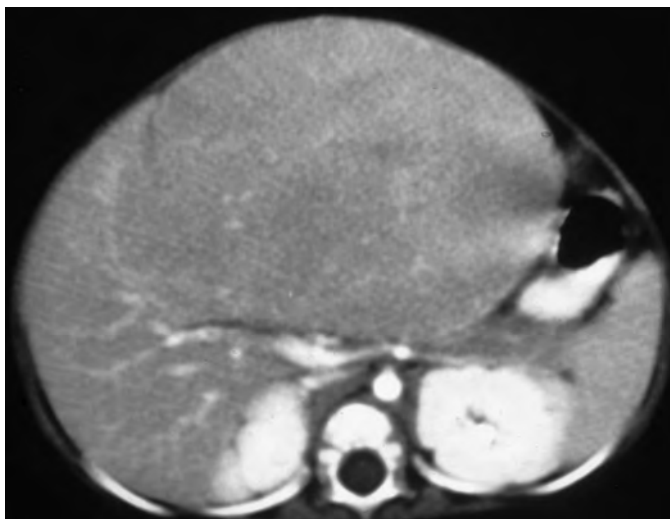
Hepatoblastoma. Contrast-enhanced CT through the upper abdomen in a 6-month-old child reveals a large isoattenuating mass arising from the medial segment of the left hepatic lobe.
